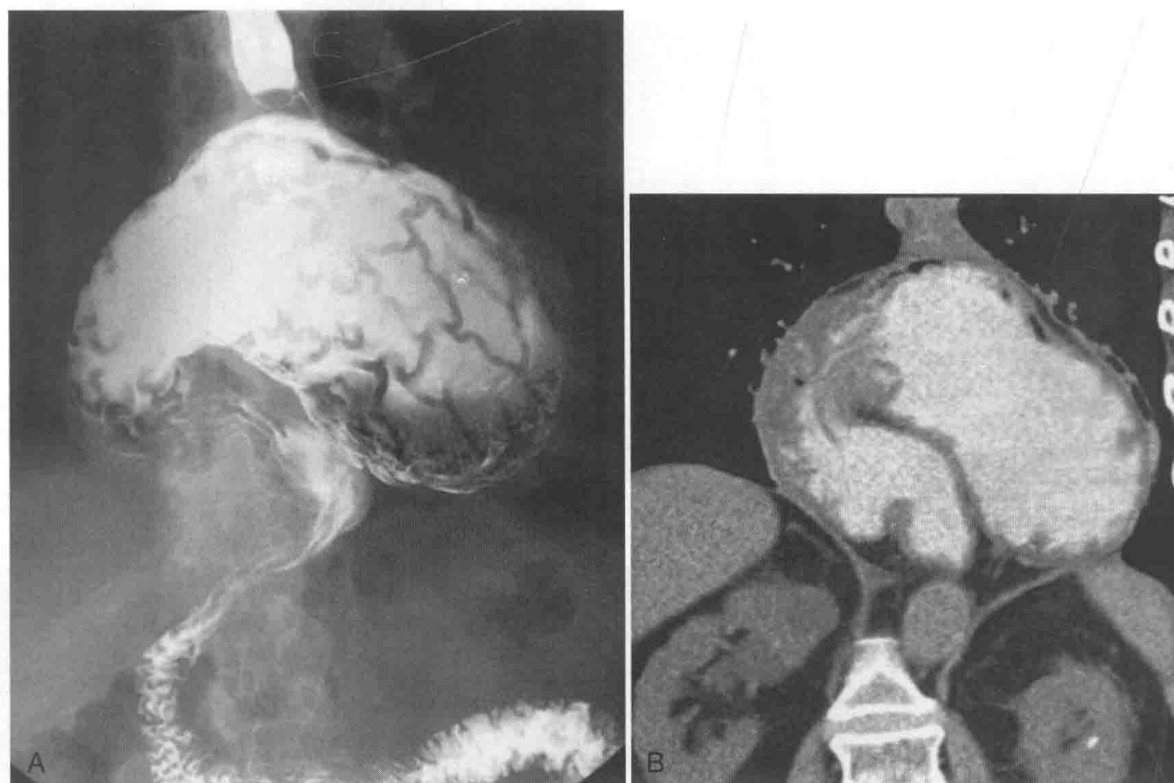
UGI series (A) and coronal noncontrast CT (B) in a 52-year-old woman with a nonobstructing organoaxial volvulus resulting in an “upside down” stomach.
